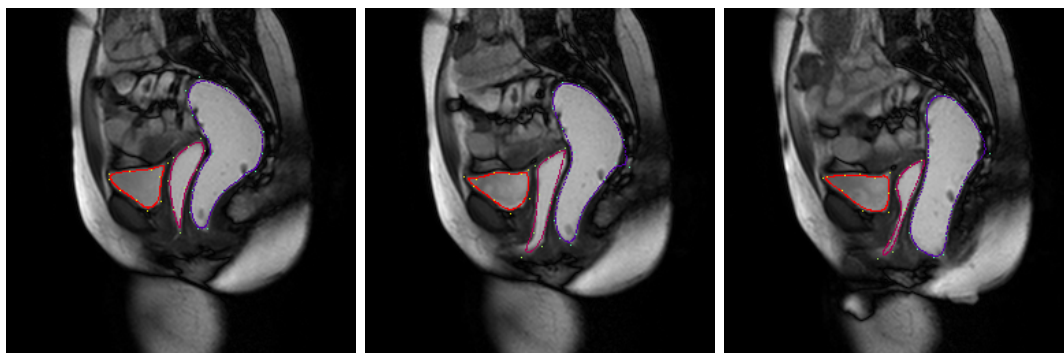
Automatic segmentation of the bladder (red contour), the vagina (pink contour) and the rectum (blue contour) on a dynamic MRI image.
